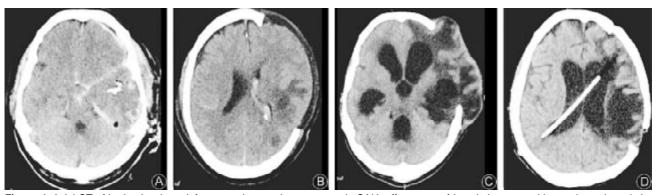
Axial CT of brain showing a left temporal contusion, a traumatic SAH, effacement of basal cisterns and bone pieces in a victim of an implanted explosive device (A). Postoperative CT scanogram of the same patient after wound debridement and a decompressive craniectomy (B). Brain CT 4 weeks after surgery showing a communicating hydrocephalus (C). Brain CT after insertion of VP shunt and cranioplasty (D).
